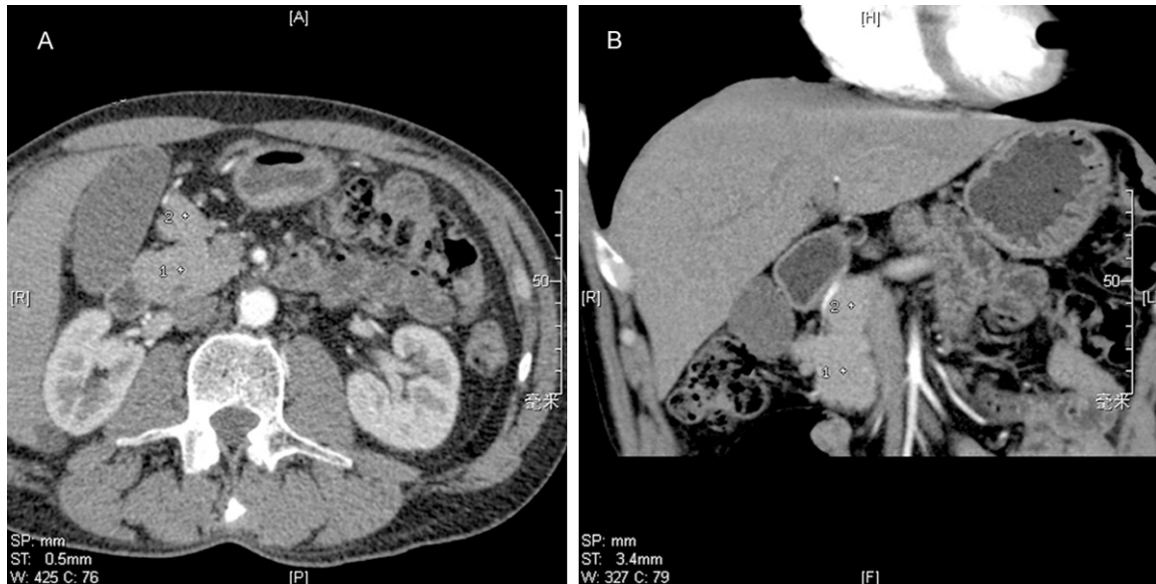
Abdominal contrast-enhanced CT images reveal the presence of a pancreatic head and uncinate process. A fat density gap shadow is visualized between the inferior pancreatic head (A) and superior pancreatic head (B).
